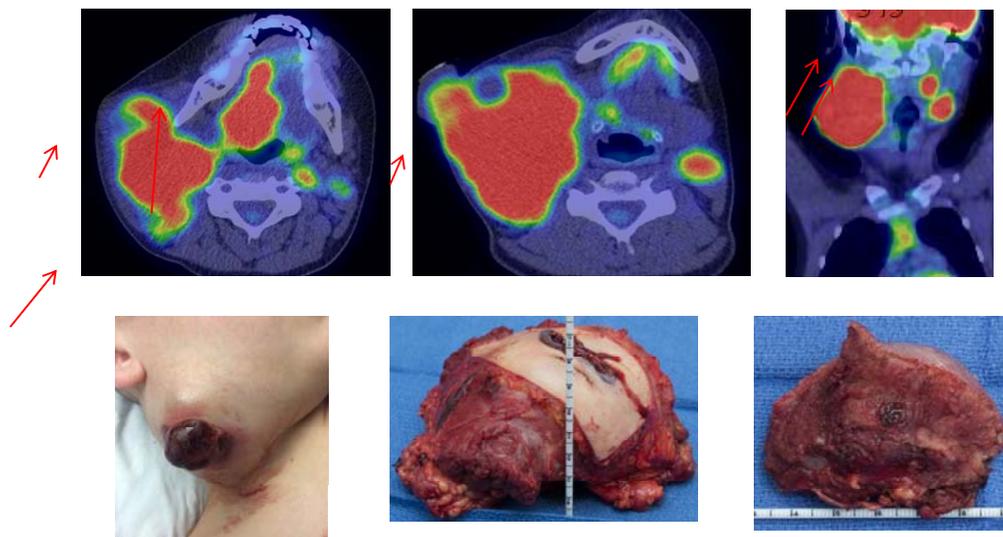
MRI of right tongue mass (long arrow), right neck mass (short arrow) and left neck nodes (double arrows).
